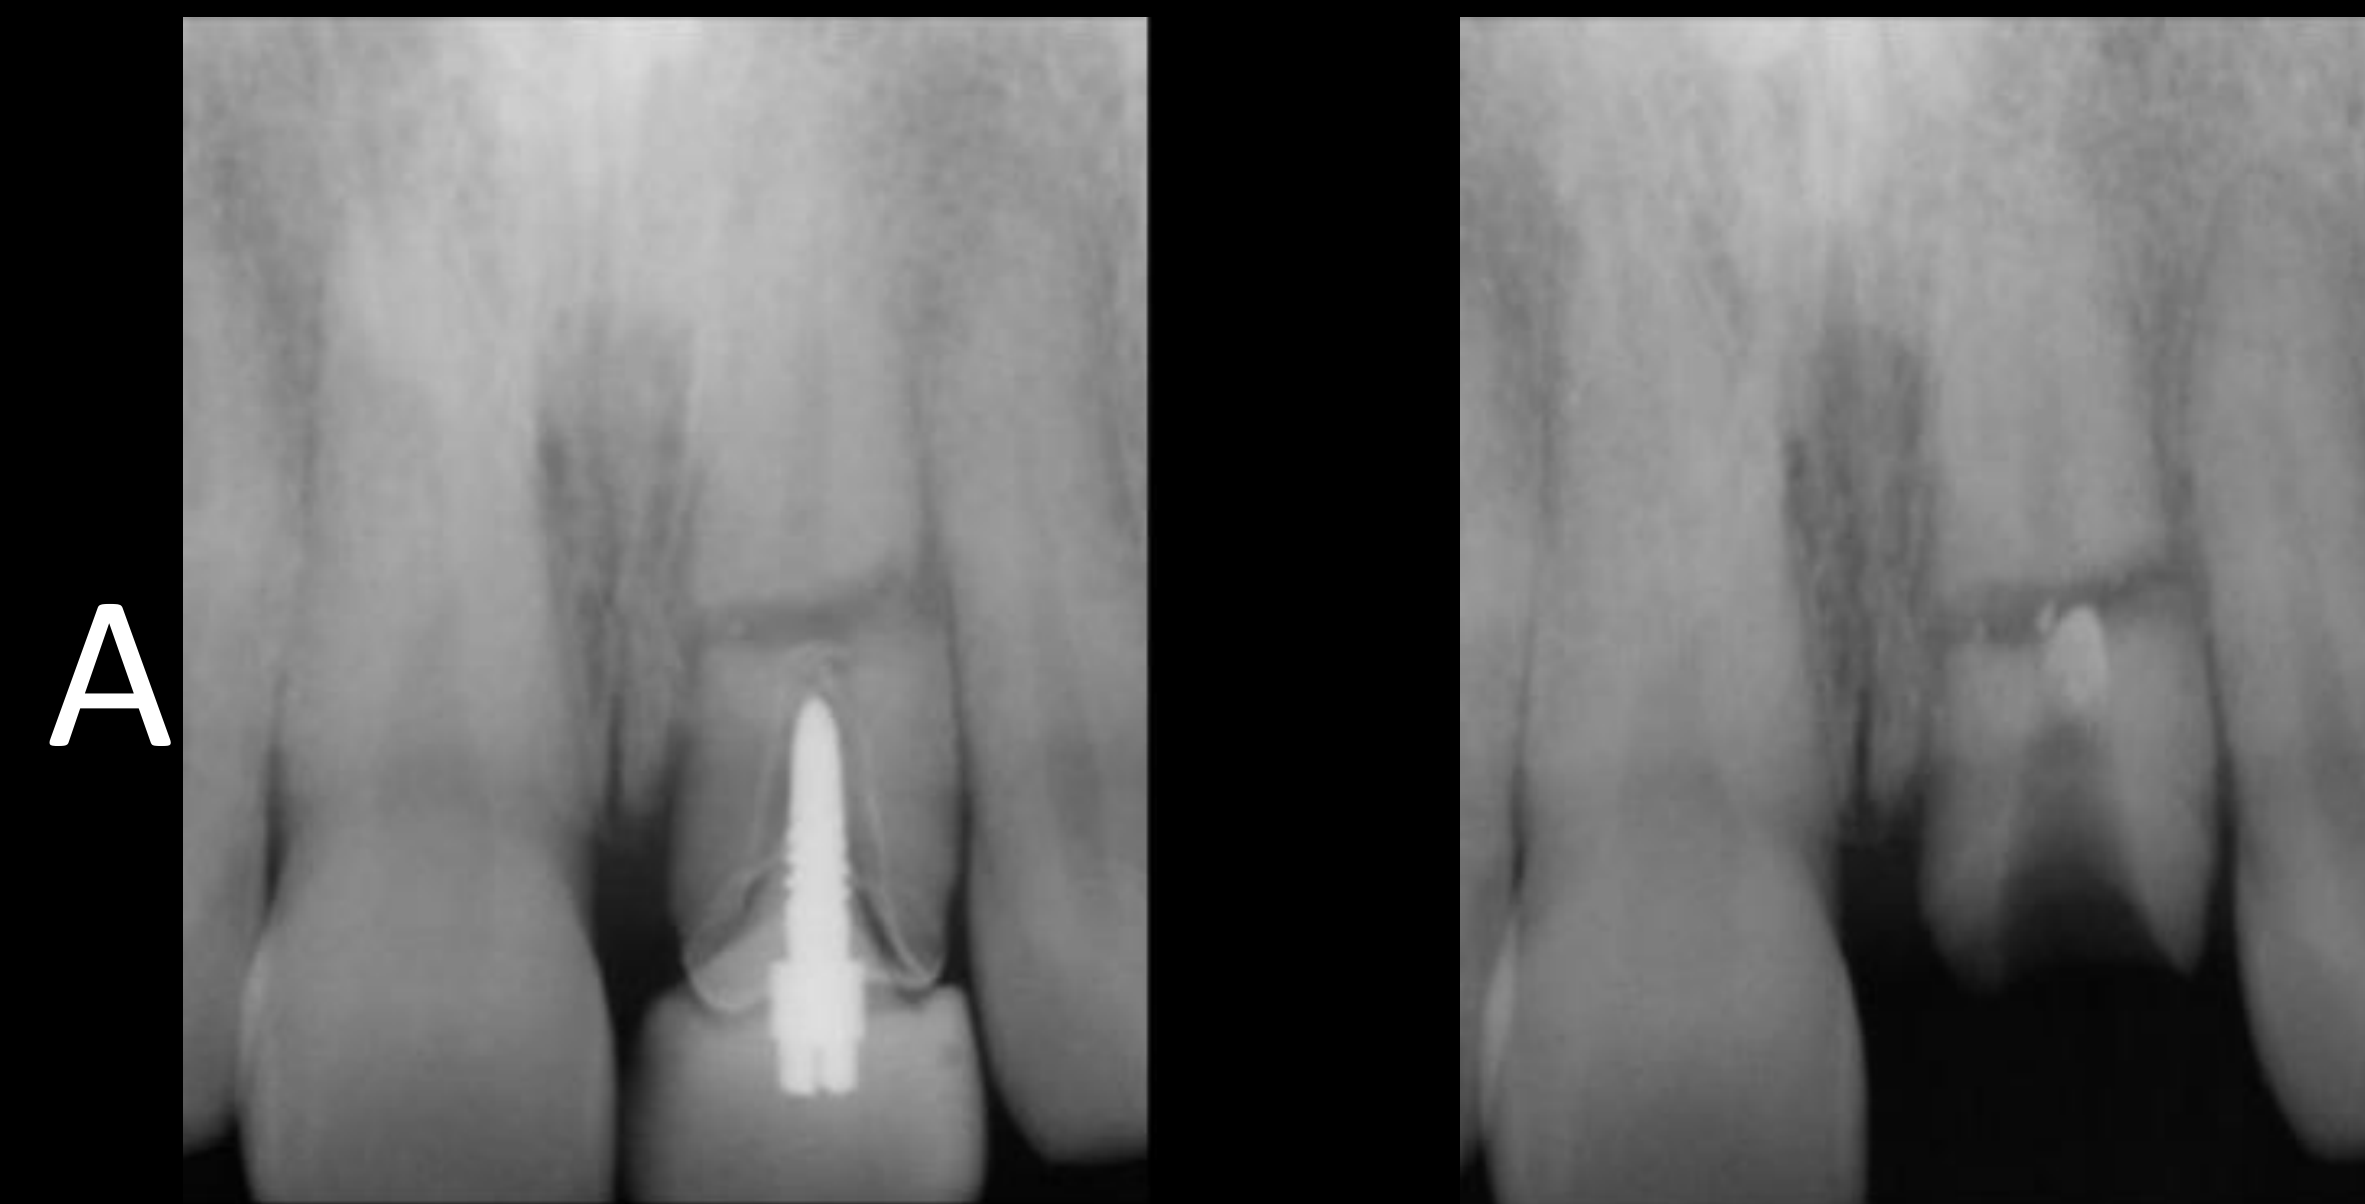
A: 2015 Pre-op x-ray horizontal root fracture #9. B: Post and crown removal 2015
